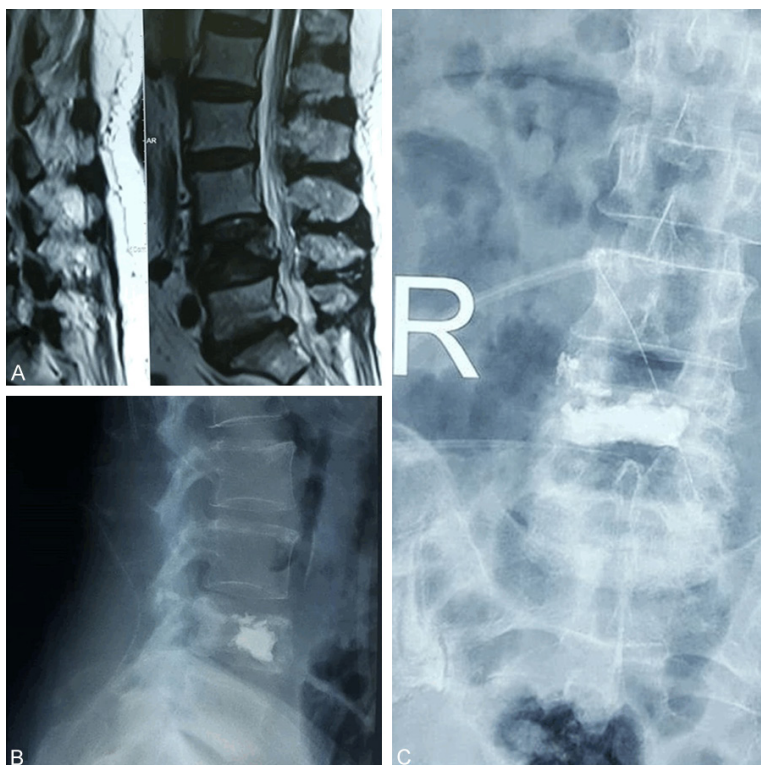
Vertebroplasty in patients. A: T2 weighted midsagittal MRI image of a subacute pincer-type fracture of L4 body. B: Plain lateral X-ray view after injecting cement. C: A-Px-ray view.
